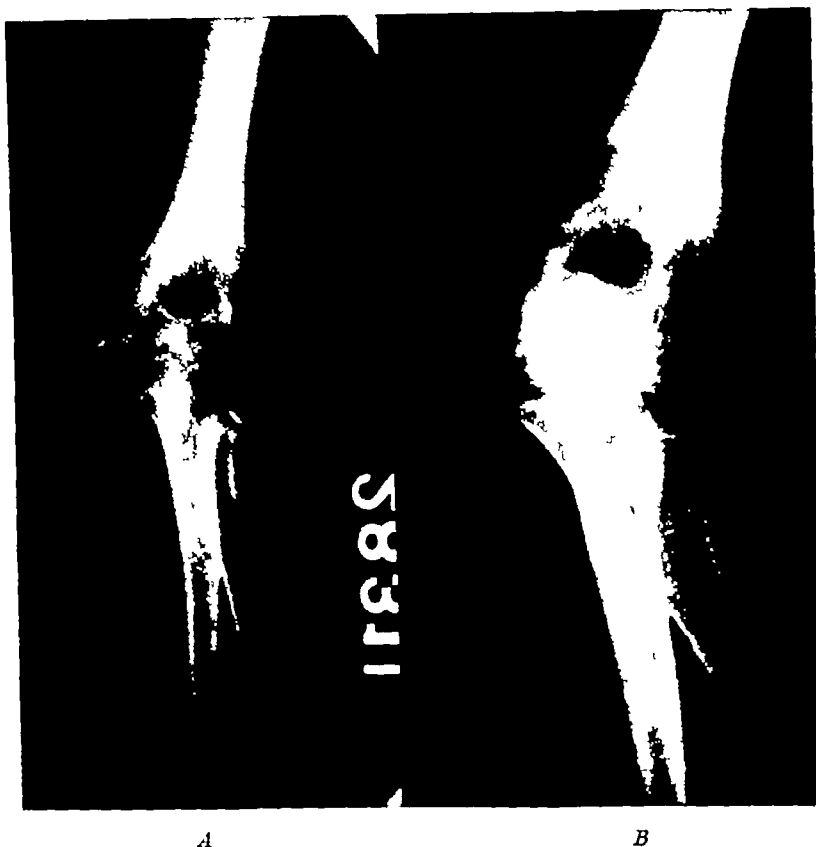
Patient is a girl, aged 11 years. Date of injury, May 2, 1929. A, Separation of the epiphysis of the medial epicondyle, with fracture of the neck of the radius. Elbow was immobilized with the alignment remaining the same. B, Roentgen study made Sept 4, 1934. There is non union of the epiphysis of the medial epicondyle and a deformity of the upper end of the radius.
